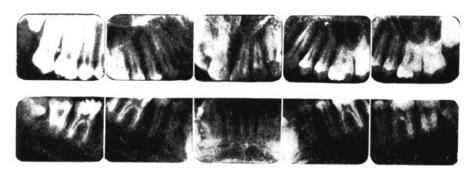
Radiographs after treatment.
